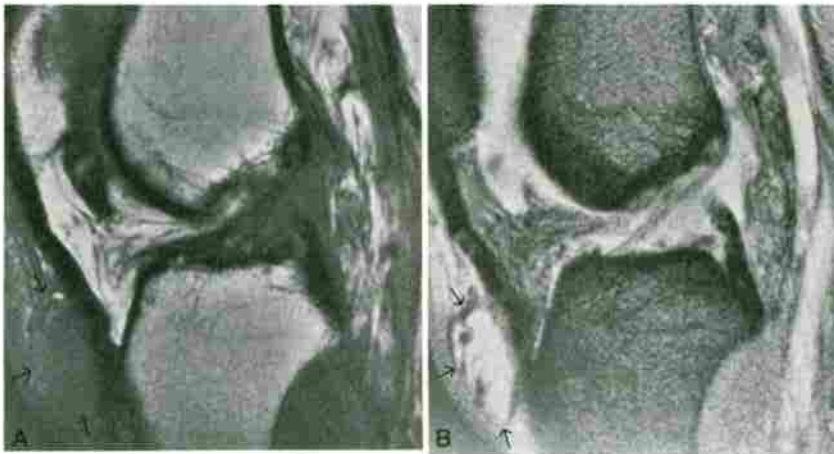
Superficial infrapatellar bursitis (arrows). A, Sagittal T1-weighted (TR/TE, 430/20) and (B) gradient-echo (TR/TE, 442/18; angle, 30 degrees) images.
